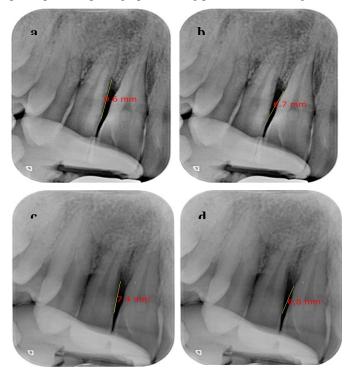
A periapical radiograph showing an intrabony defect between an upper central and lateral. a. preoperative linear measurement of the distance from the CEJ to the depth of the intrabony defect. b. Pre-operative linear measurement of the distance from the CEJ to the alveolar crest. c. Six months post-operative linear measurement of the distance from the CEJ to the depth of the intrabony defect. d. Six months post-operative linear measurement of the distance from the CEJ to the alveolar crest.
